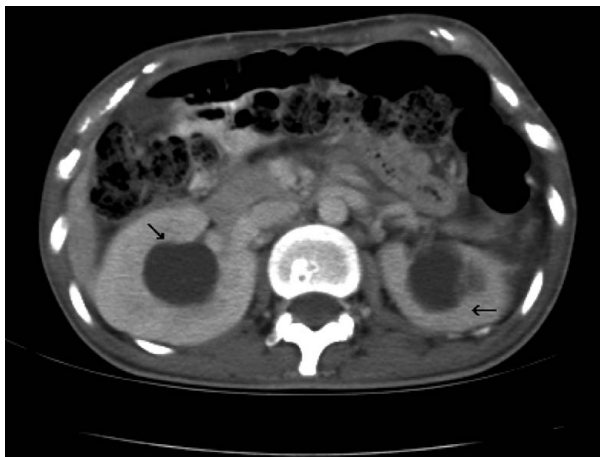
Computed tomography scan with contrast. The arrows indicate bilateral hydronephrosis.
